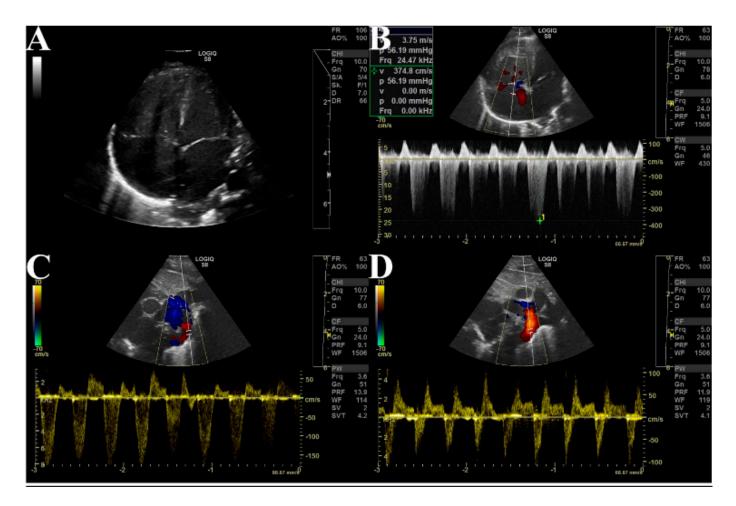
Pediatric Critical Care–Medical Hemodynamic Stabilization with Prostaglandin E1. Note: hemodynamic instability in a 1-day-old patient with VGM Lasjaunias Type 1 "choroidal" documented with echocardiography and ultrasonography; (A) suprasystemic increased right ventricular pressure as a sign of right ventricular decompensation; (B) insufficiency of the tricuspid valve as an indirect sign of increased pulmonary arterial pressure; (C) patent ductus arteriosus botalli with predominant right-to-left shunt; (D) retrograde flow in the descending aorta (so-called "aortic steal effect").
